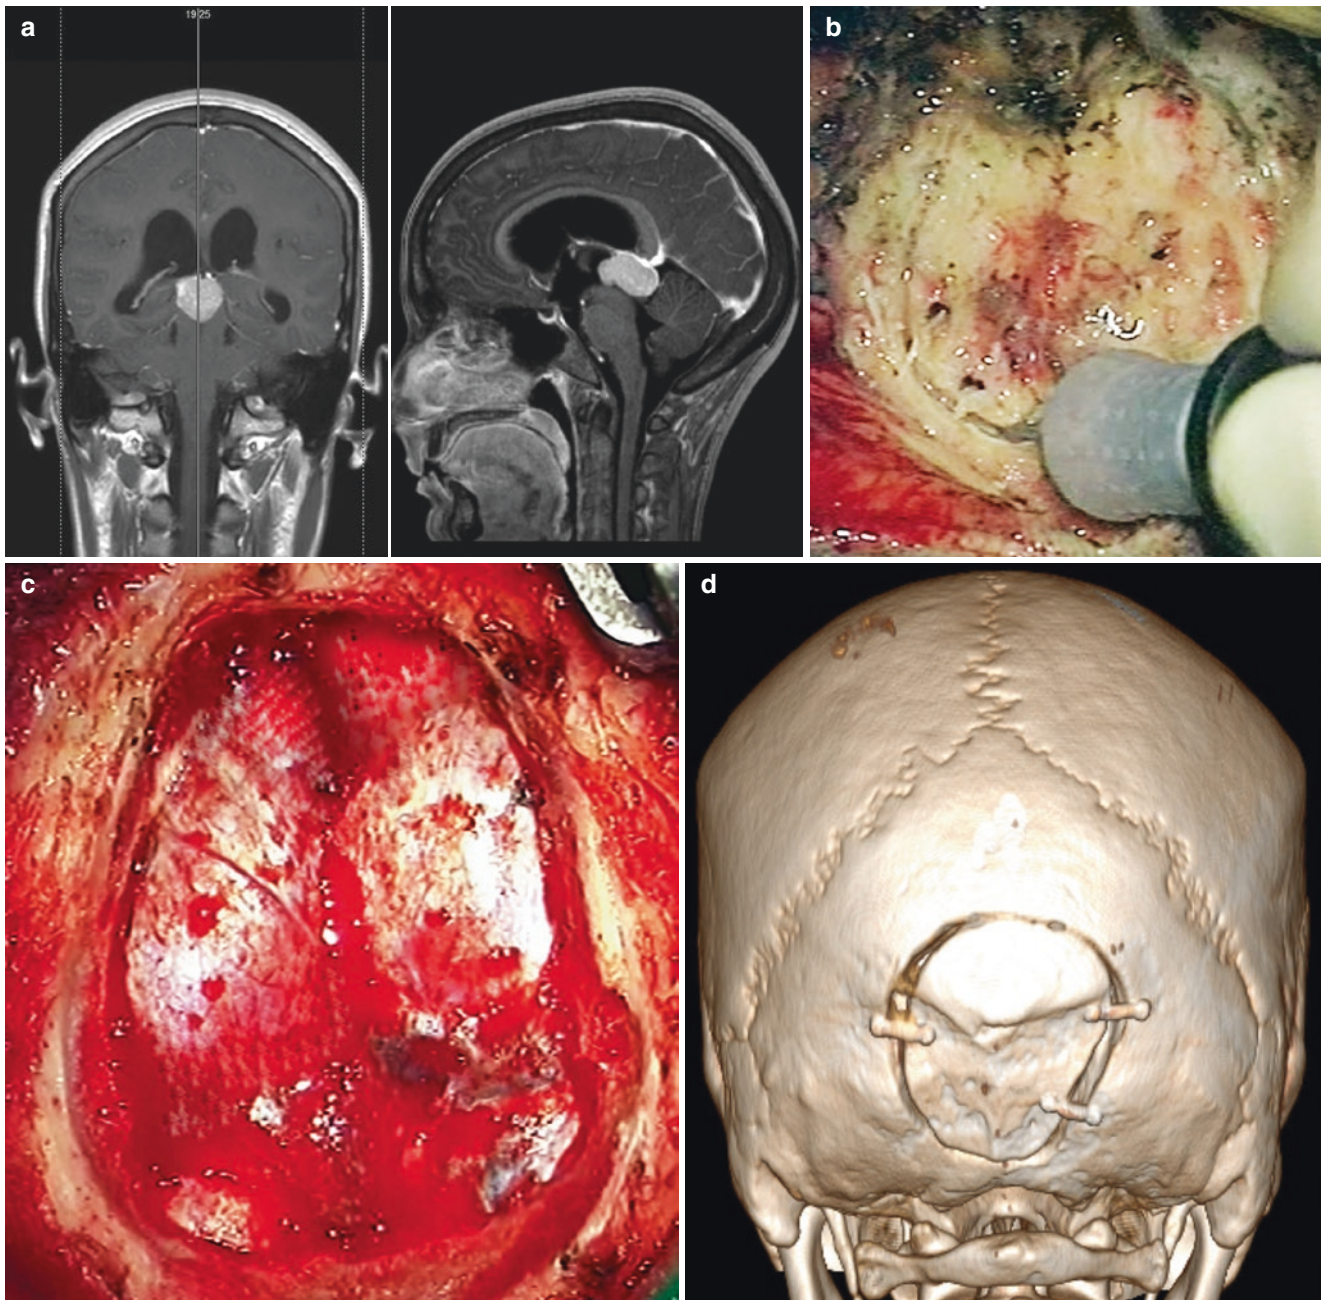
Coronal and sagittal T1-weighted brain MRI images with Gadolinium showing a pinealoma. (a) Occipital craniotomy performed using the BoneScalpel™ blade shaver (b) that crossed the posterior
